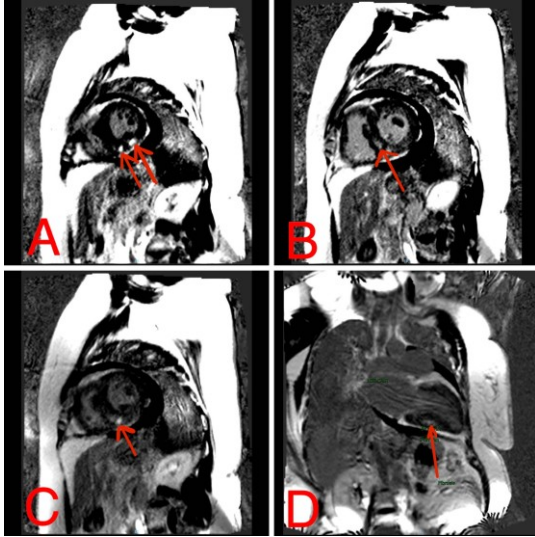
Short axis Cardiac MRI showed multifocal Late Gadolinium Enhancement (LGE) of the inferior and infero-septal LV wall. A: apical wall. B: basal wall. C: mid septum wall. D: Two chambers view.
